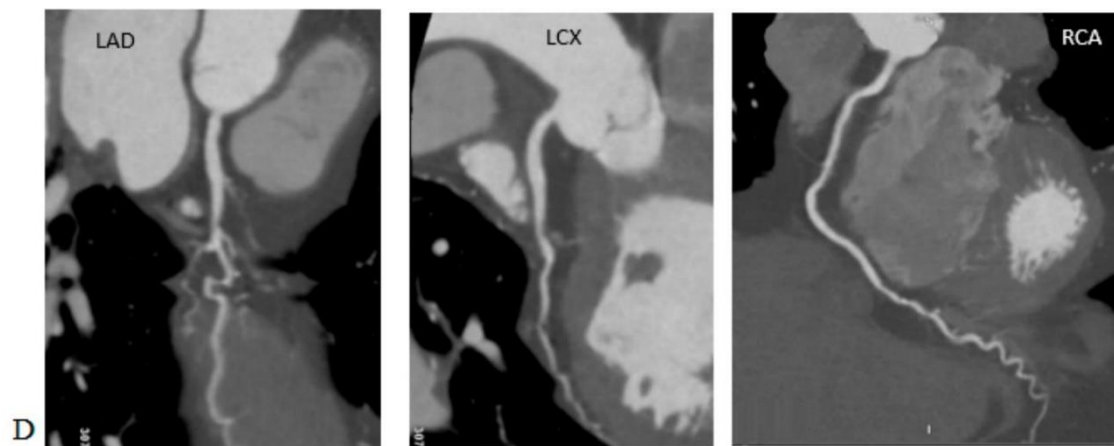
Coronary artery computed tomography scans performed on various scanners, using iterative reconstructions and AI algorithms. Note the DLP and effective dose (ED) of the studies and compare them to the image quality. (A) 120 kVp, DLP 1684.6 mGy*cm, ED = 23.58 mSv ($k = 0.014$ mSv/mGy*cm), iterative reconstruction. (B) 100 kVp, DLP 712.2 mGy*cm, ED = 9.97 mSv ($k = 0.014$ mSv/mGy*cm, reconstruction with AI algorithms). (C) 100 kVp, DLP 715.7 mGy*cm, ED = 10.02 mSv ($k = 0.014$ mSv/mGy*cm), iterative reconstruction. (D) 100 kVp, DLP 99.7 mGy*cm, ED = 1.40 mSv ($k = 0.014$ mSv/mGy*cm), reconstruction with AI algorithms.
